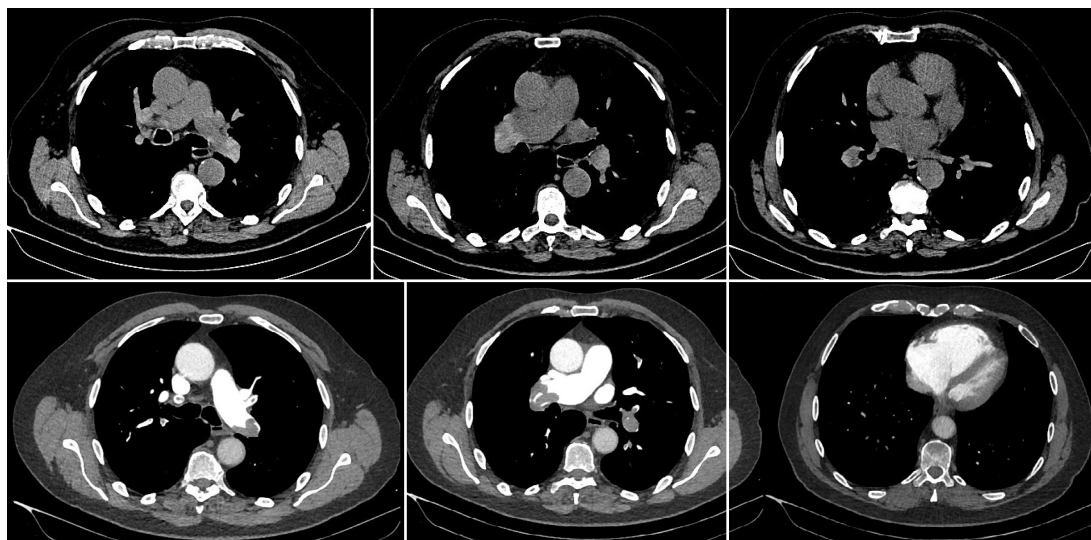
Hyperdense clots in the main pulmonary artery on unenhanced CT, confirmed by CT pulmonary angiography showing bilateral embolism and right heart strain.
